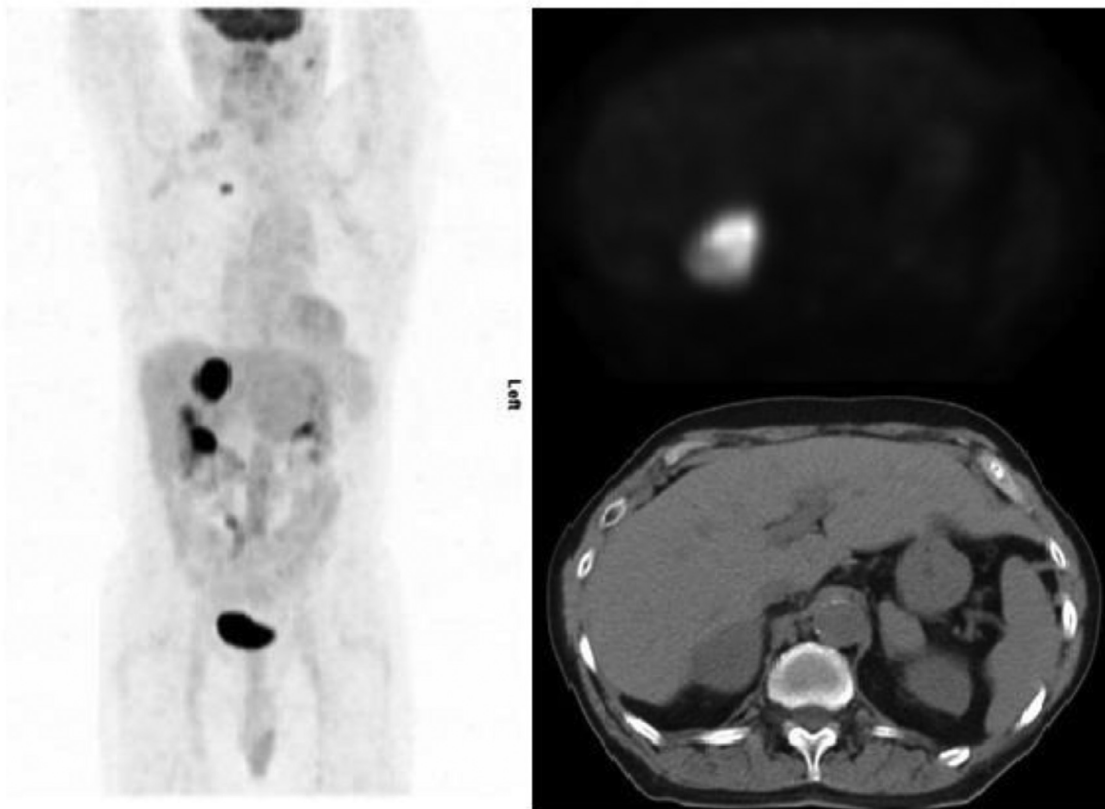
MIP image showing hypermetabolic right-sided adrenal mass and upper lobe nodule (on the left) and axial slice of PET and corresponding CT showing adrenal mass (on the right). Both are from the PET-CT performed in April 2012. MIP, maximal intensity projection; PET, positron emission tomography; CT, computed tomography.
